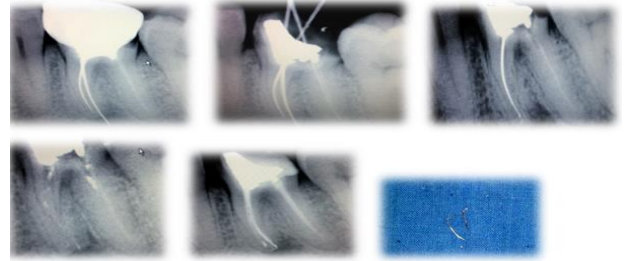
An intraoral periapical radiograph indicates silver point obturation in 46.
